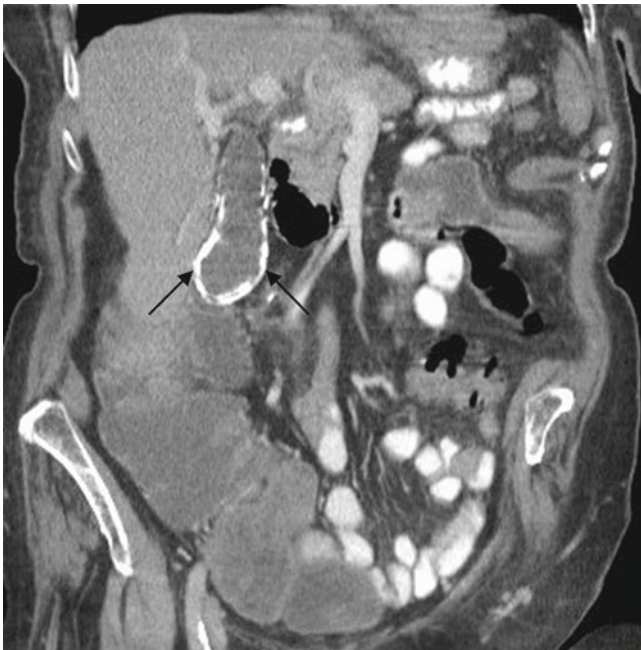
A 75-year-old woman with upper abdominal pain. Coronal reconstructed oral and intravenous contrast enhanced CT image shows calcified gallbladder wall (*black arrows*). Diagnosis: Porcelain gallbladder
